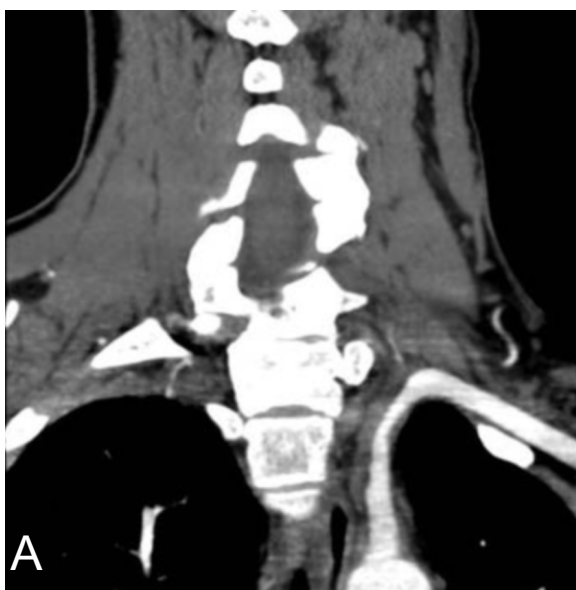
Coronal CT with contrast, demonstrating narrowing of the left subclavian artery (without color in 5A, filled in red in 5B) with a surrounding crescent of soft tissue density (without color in 5A, outlined in yellow in 5B).
